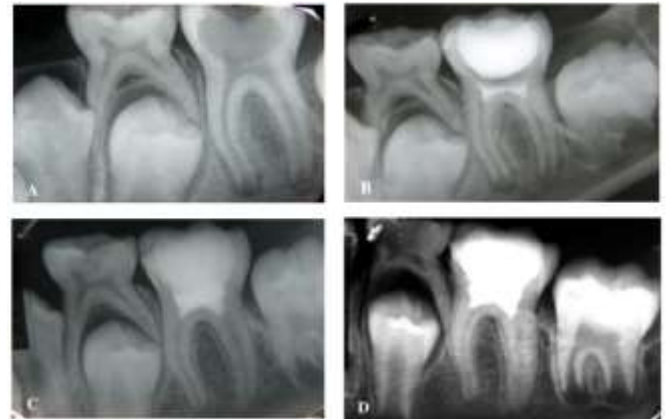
Radiography of case No. 250 undergoing MTA pulpotomy, A: Primary radiography; B: Radiography after epoxogenesis; C: Radiography after 6 months; D: Radiography after 12 months
